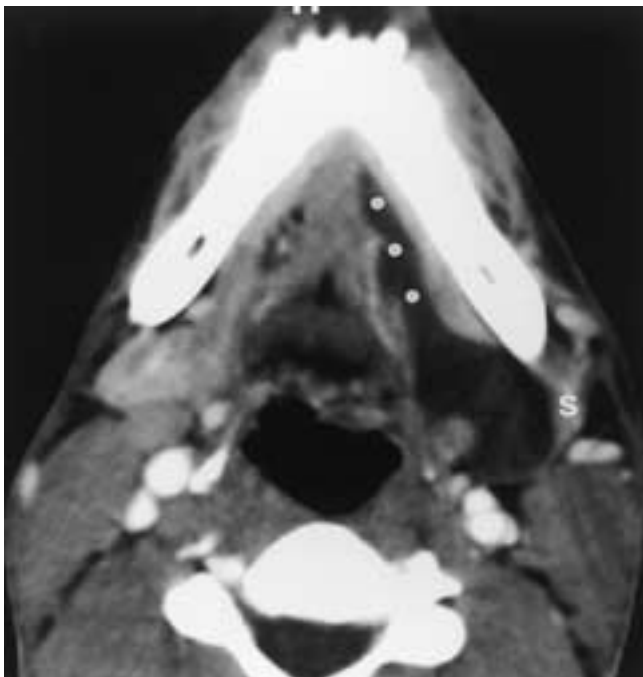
Plunging ranula. Axial contrast-enhanced CT scan reveals a cystic lesion in the left submandibular region with a visible ‘tail’ in the left sublingual space (*dots*). The left submandibular gland (S) is compressed and displaced laterally.
